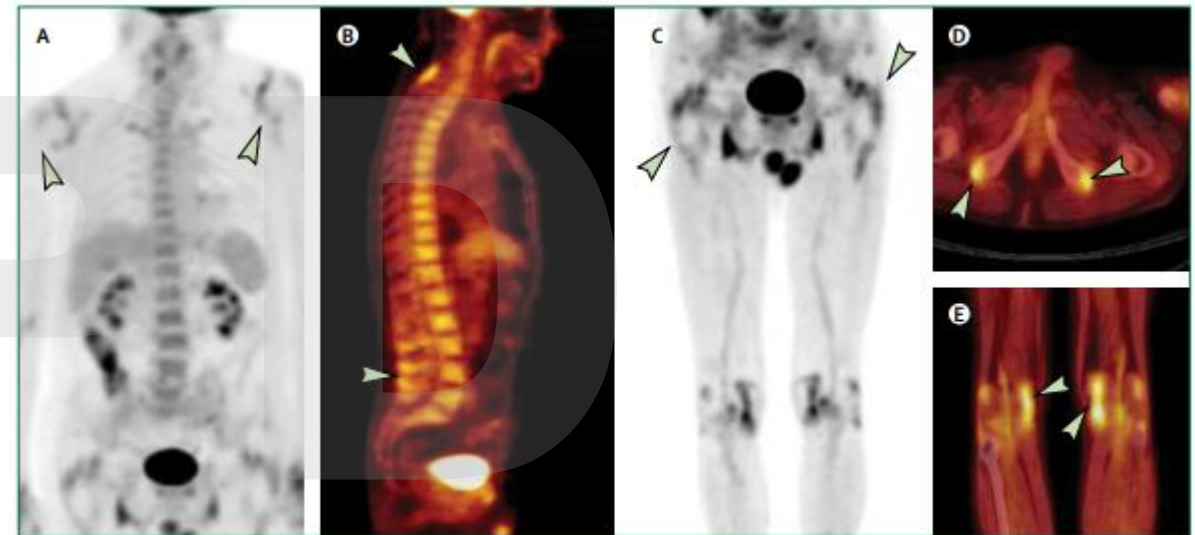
FDG-PET integrated with CT images in a 75-year-old man with polymyalgia rheumatica
